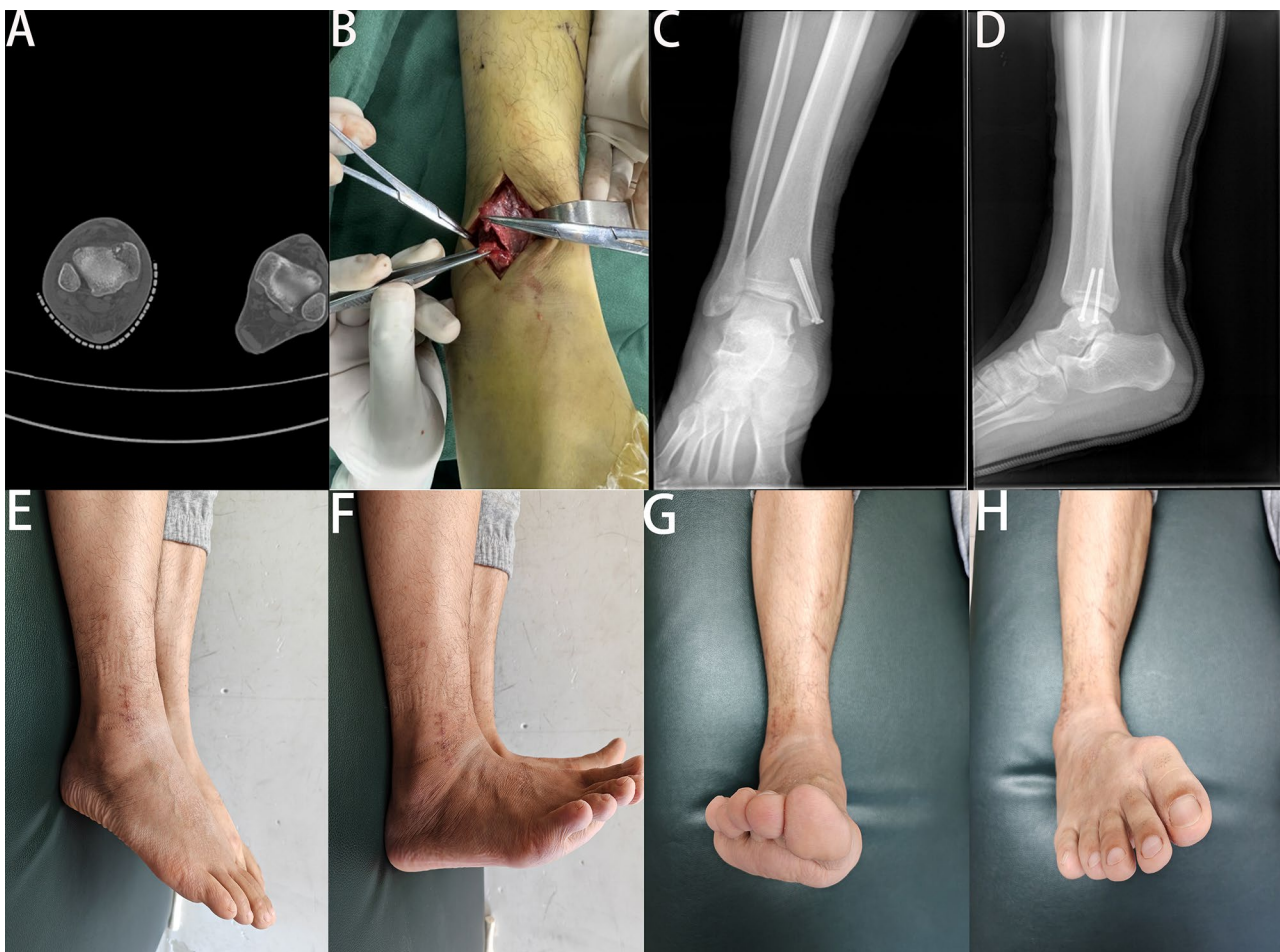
A Preoperative CT scan demonstrating a medial malleolar fracture and Tillaux fracture of the right ankle joint. B Intraoperative findings revealing a rupture of the peroneus tertius muscle. C and D Postoperative follow-up X-ray images. E Postoperative photograph at 4 months showing ankle in plantarflexion. F Postoperative photograph at 4 months showing ankle in dorsiflexion. G Postoperative photograph at 4 months showing ankle in eversion. H Postoperative photograph at 4 months showing ankle in inversion
